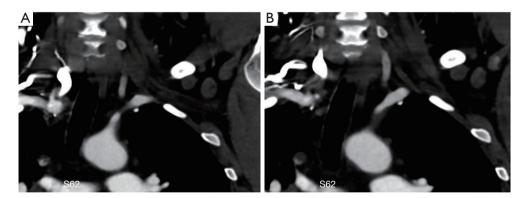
Two axial CTA images (A,B) of the left upper extremity with injection of iodine based contrast via a right peripheral intravenous access showing mild stenosis at the proximal portion of the left subclavian artery. CTA, computed tomography angiography.
